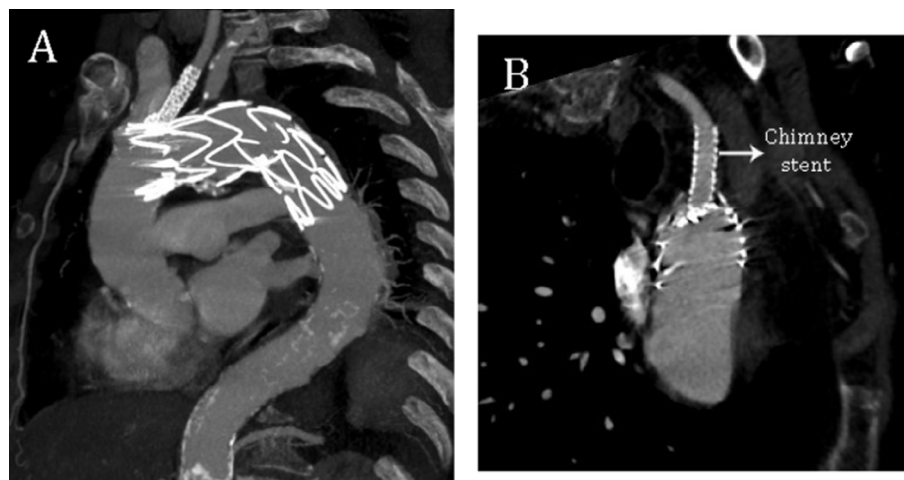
Postoperative CTA: (A) and (B) confirm the excellent exclusion of the aortic-arch PsA, no significant endoleak, and the patency of both aorta and LCCA. CTA = computed tomography aortogram; LCCA = left common carotid artery; PsA = pseudoaneurysm.
